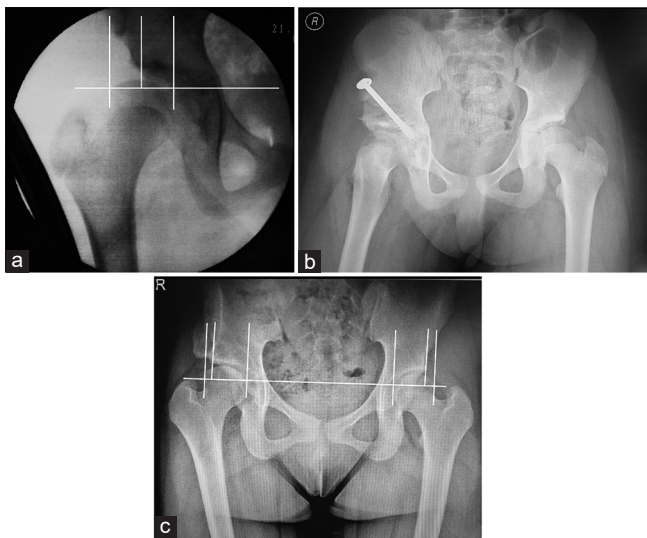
An 11-year-old girl who has had surgery of the right hip for DDH presented with pain and limping on the right hip. (a) Pre-operative image intensifier radiograph shows persistent acetabular dysplasia with 45% uncoverage of the femoral head. (b) Immediate post-operative radiograph after pemberton acetabuloplasty fixed with a cannulated screw without cast. (c) Fourteen years after surgery, she reports no hip pain and good hip function. Standing pelvis radiograph shows good femoral head coverage even in adduction identical to the other hip (16% uncoverage) with mild coxa magna.
